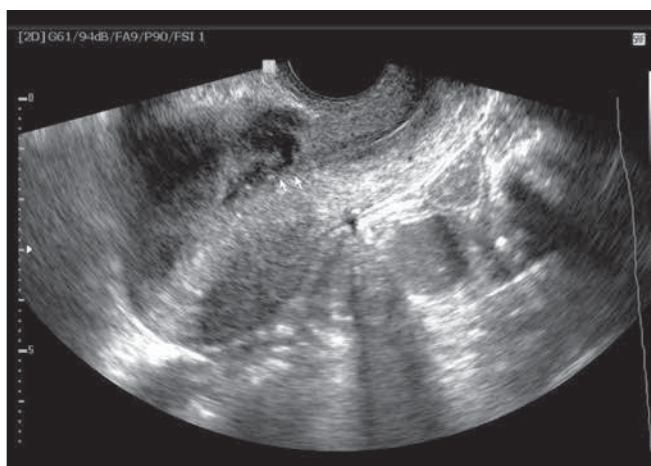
Three weeks after UAE a transvaginal ultrasound examination demonstrated an empty uterine cavity and no sonographic abnormalities in the region of the cesarean scar.
